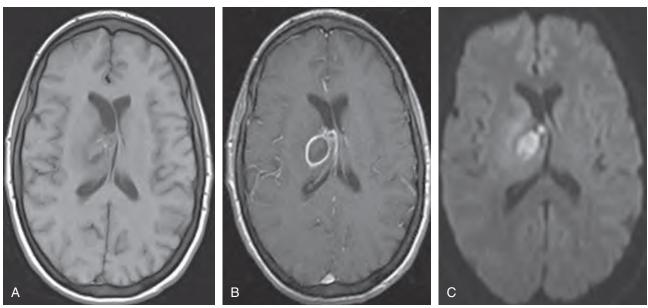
Magnetic resonance imaging of the brain reveals a 3 × 1.7 cm bilobed peripherally enhancing, centrally restricted brain abscess located within the right thalamus. (A) T1-weighted image. (B) T1-weighted image after administration of gadolinium reveals ring enhancement of the abscess. (C) Diffusion-weighted imaging reveals marked hypersignal, a finding consistent with pyogenic brain abscess.
